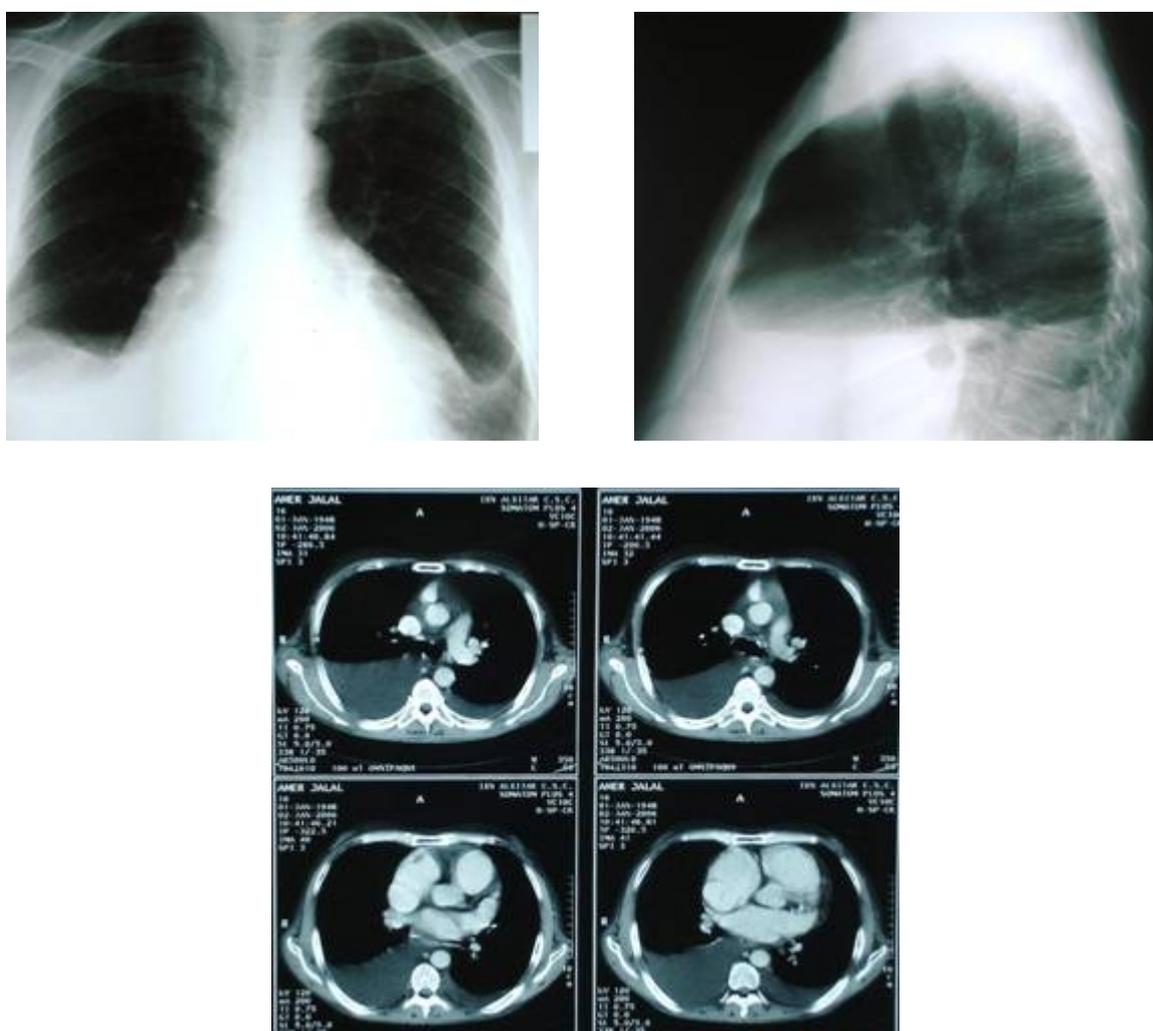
Preoperative chest x-rays and ct-scan showing huge heart with with evidence of pleural effusion
